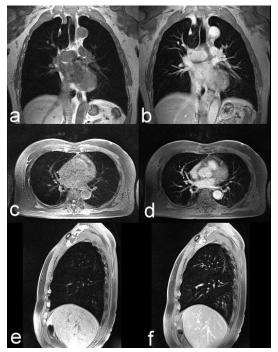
Comparison of VIBE images from MRI without and with the use of contrast.
